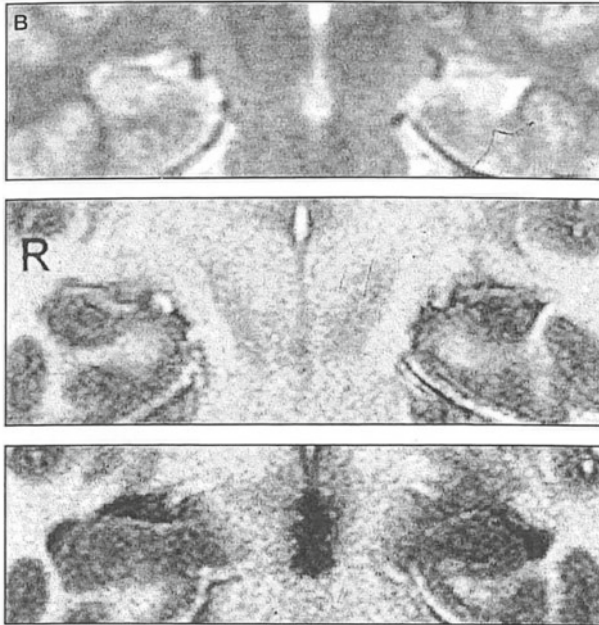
MRI findings in hippocampal sclerosis. Coronal T1-weighted MRI scan showing right-sided hippocampal sclerosis. With kind permission of Springer Science+Business Media: *Epileptic Syndromes and their Treatment*, 2010, p. 447, Panayiotopoulos, C., Fig. 15.5
